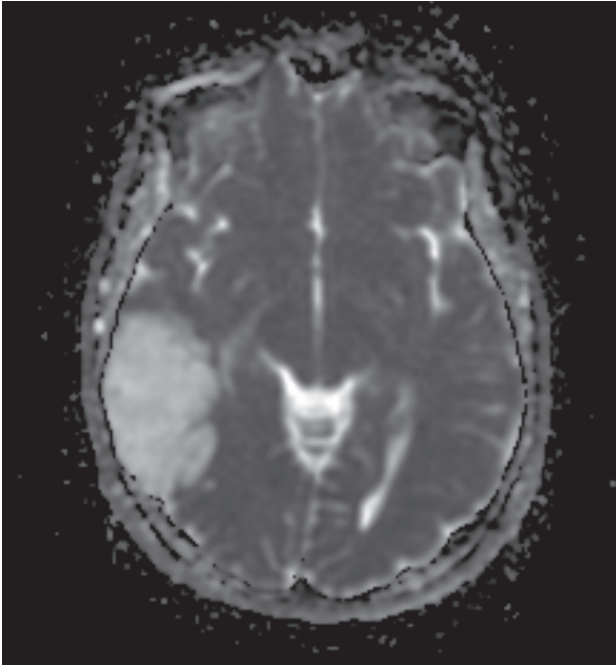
ADC Mapping of DWI sequence showing a temporal region lesion showing heterogeneous diffused signals.
